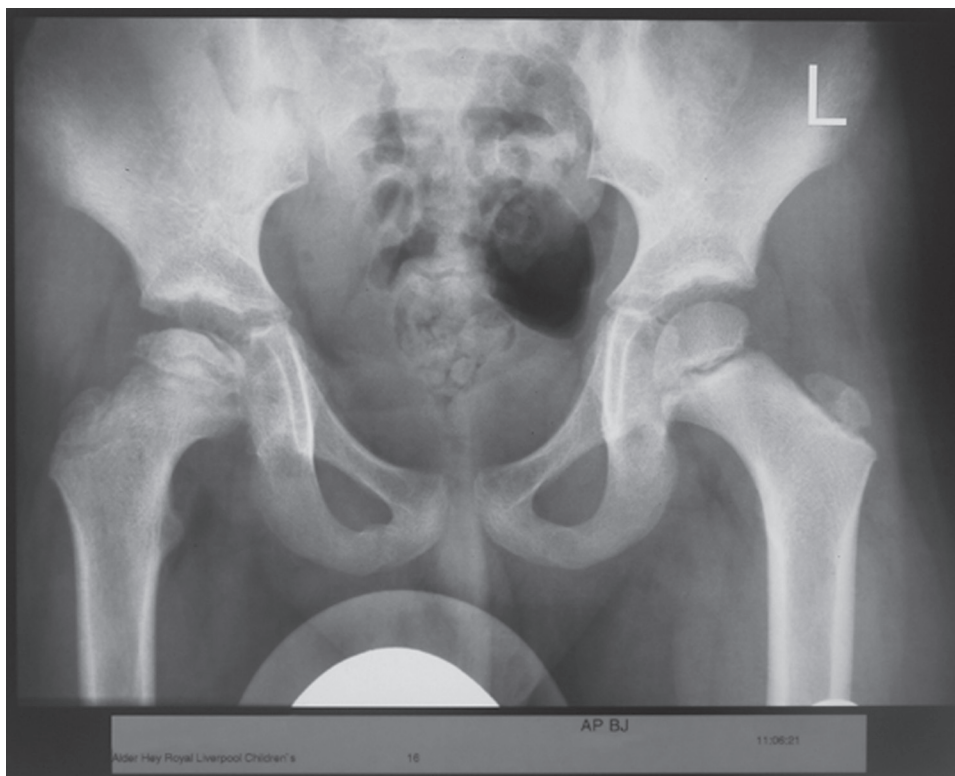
Radiograph at 6 months postreduction. The right femoral epiphysis is seen to be sclerotic and flattened with evidence early fragmentation. This is typical of changes seen in avascular necrosis.
